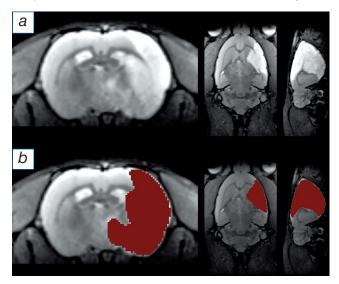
An example of segmentation of the cerebral infarction using artificial intelligence: a — T2-weighted images in the axial, frontal and sagittal planes (from the left side to the right), in which the right hemisphere contains a visualized hyperintensive infarction focus in the brain; b — automatic segmentation of the cerebral infarction focus (marked with red color).
